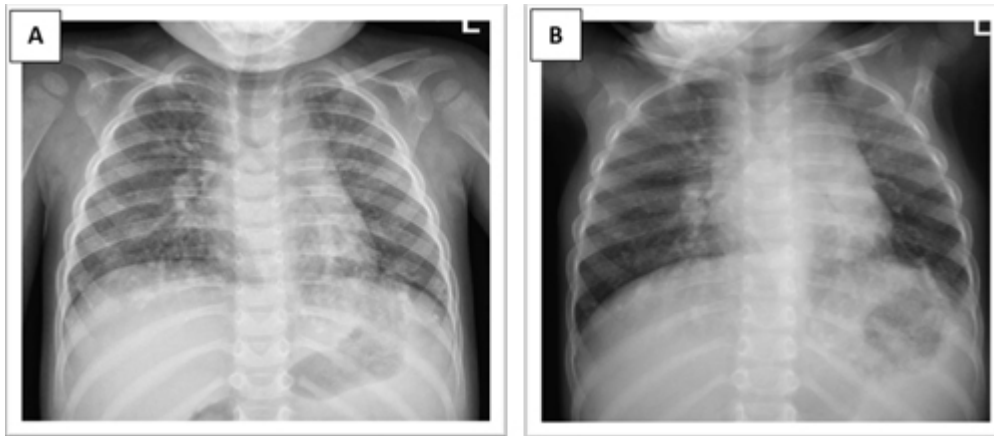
Initial chest X-rays. ↩
